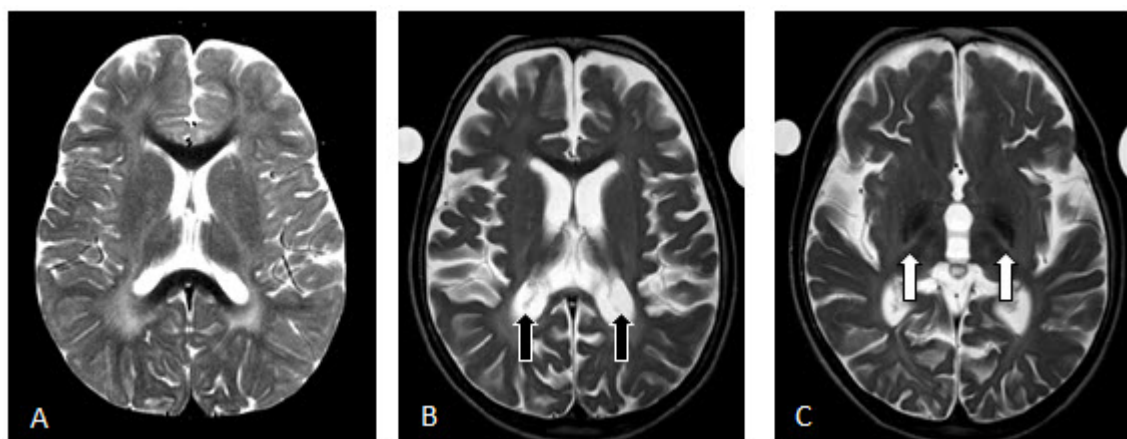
Brain MRI findings in a child with the late-infantile form of GM1 gangliosidosis
